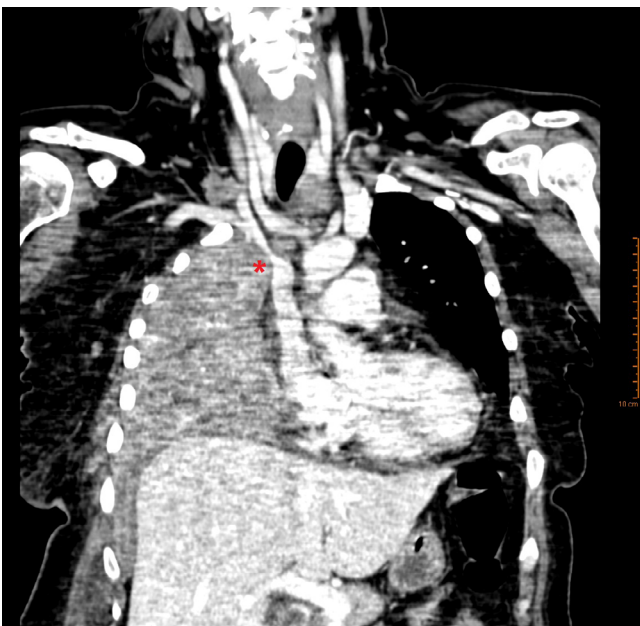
Chest CT scan (coronal reconstruction) – mass in the right pulmonary Apex, which caused compression and important reduction of caliber of the right subclavian vein at the opening to the superior vena cava (asterisk).
